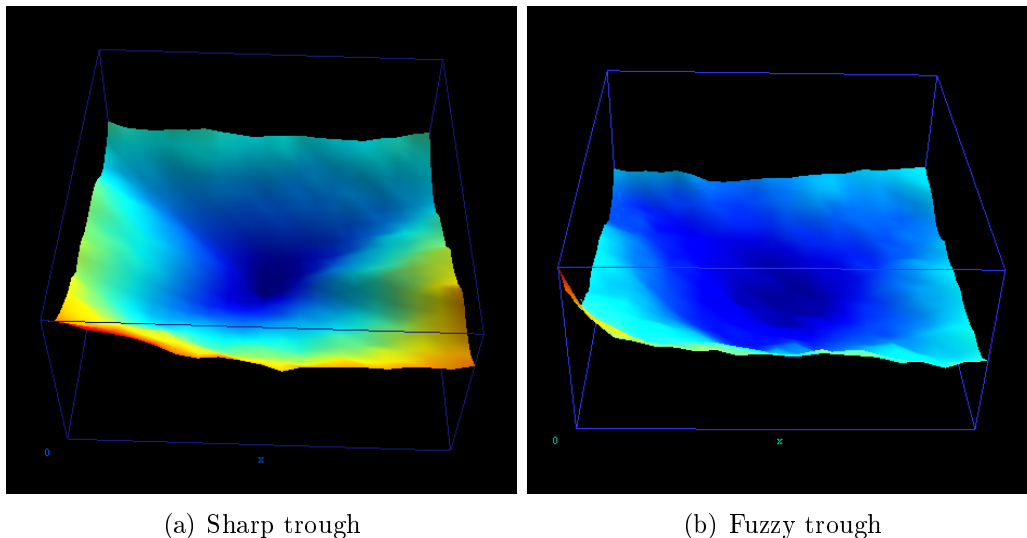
Cost function plot using the Beaton-Tukey M-estimator for the out-of-plane parameters – translation along the  $z$  axis and rotation around the  $x$  axis. (a) shows a small but sharp funnel as the synthetic slice was not deformed whereas (b) shows a fuzzy area since the synthetic slice contains deformation. The information of the CT-fluoro slice is thus dispersed into a subvolume of the CT data set.
